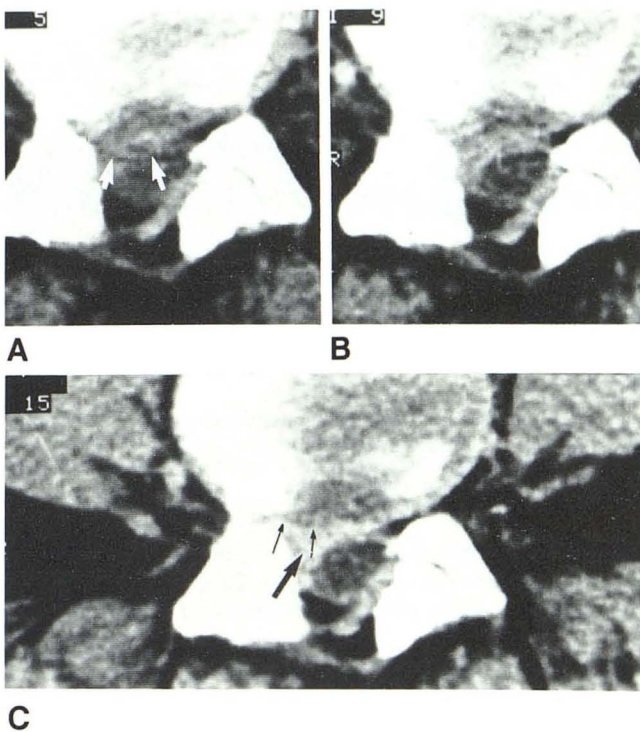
Recurrent herniated disk: failure of detection by enhancement technique. A, Preenhancement. Annular bulge (arrows) on right and center of canal had appearance of herniated disk, although CT density was not as high as usual. B, After 100 ml of contrast material. Enhancement is not marked. C, After 150 ml of contrast material. Enhancement appears more intense. Enhanced triangular scar (large arrow) extends from dural sac to "anulus." Slight but definite focal bulge of anulus (small arrows) was not considered significant. At surgery bulge anterior to scar proved to be part of a larger recurrent herniated disk.
